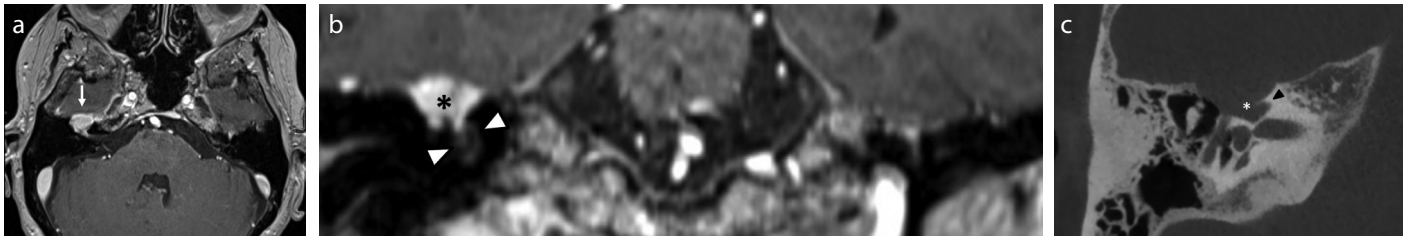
a-c. (a) Axial gradient echo T1-weighted image. The facial nerve schwannoma (arrow) is centered on the geniculate ganglion region on the right side with extension in the labyrinthine segment. (b) Coronal multiplanar reconstruction of a 3D gradient echo T1-weighted sequence at the level of the geniculate ganglion demonstrates the communication between the facial nerve schwannoma (asterisk) and the adjacent cochlea (arrowheads).
